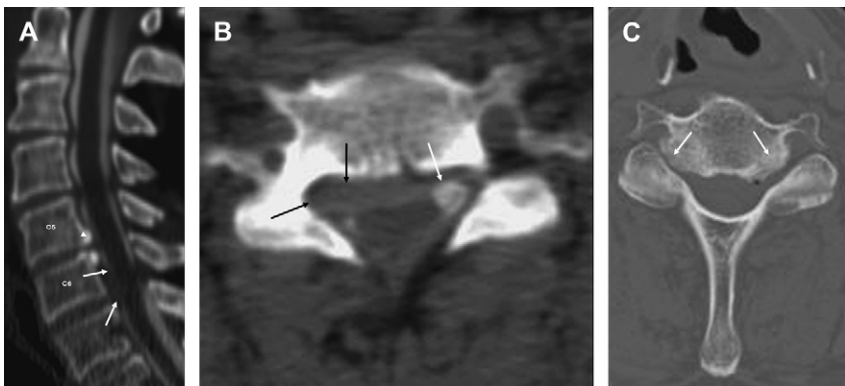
Cervical degenerative disk disease. (A) Reconstructed sagittal CT myelogram—patient who had right C7 radiculopathy, anterior epidural defect dorsal to C6 body (arrows). (B) Axial CT myelogram, same patient—better shows thecal sac compression resulting from disk extrusion (dark arrows). Note intact left lateral recess thecal sac and nerve root (white arrow). Also, note bony dominant hypertrophic change at C5-6 (A) (arrowhead) with mild impression on thecal sac. (C) Axial nonmyelographic CT—different patient who had bilateral uncovertebral joint spurring (arrows) resulting in foraminal stenosis.
